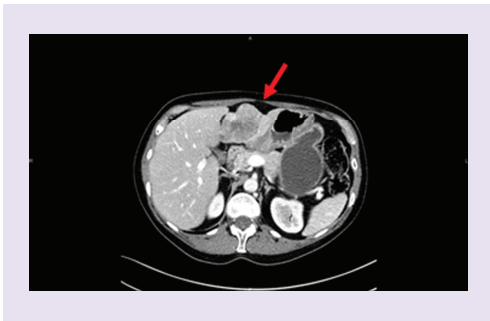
CT scan showing partial response of liver lesion (June 2012).
